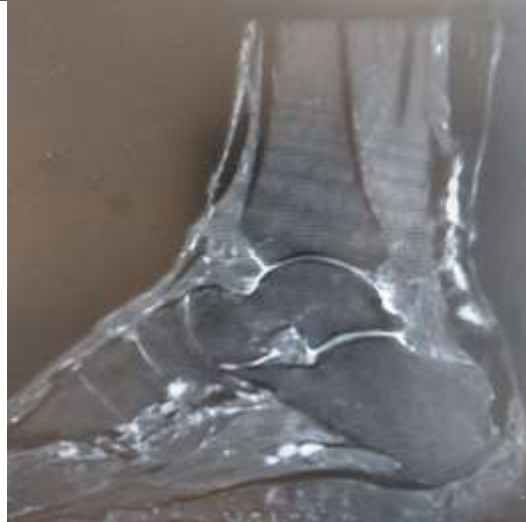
MRI of the ankle showing a 7 cm gap between the 2 ends with intermediate fibrosis
